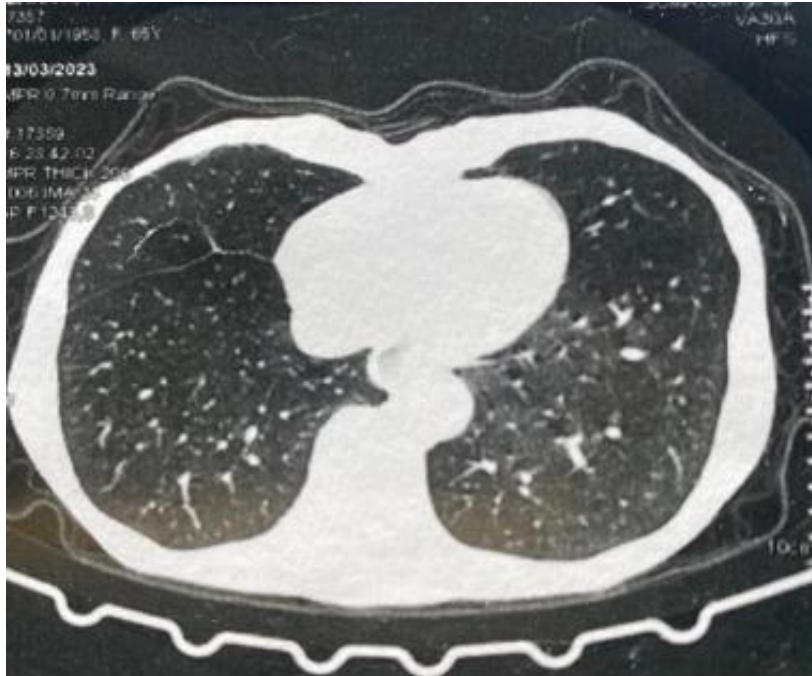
Thoracic CT scan showing pulmonary emphysema
